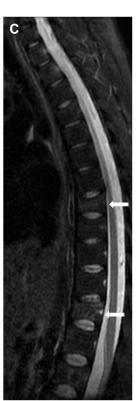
A, Lumbar plain radiography showing T8 and T12 vertebral fractures. B, T1-weighted MRI demonstrating vertebral fractures at T8, centered at the superior end plate and anterior column, with mild wedging and an estimated height reduction of 35%, without significant retropulsion of the posterior wall and at T12, exhibiting a biconcave morphology, with an estimated height reduction of 30%, also without significant retropulsion of the posterior wall. C, T2-weighted fat-suppressed Dixon/IDEAL MRI demonstrating vertebral fractures at T8 and T12, with associated bone marrow edema at both levels. D, STIR-weighted MRI demonstrating L2 vertebral body fracture with associated bone marrow edema, exhibiting a biconcave morphology and an estimated height reduction of 25%, without significant retropulsion of the posterior wall. IDEAL, iterative decomposition of water and fat with echo asymmetry and least-squares estimation; MRI, magnetic resonance imaging; STIR, short τ inversion recovery.
